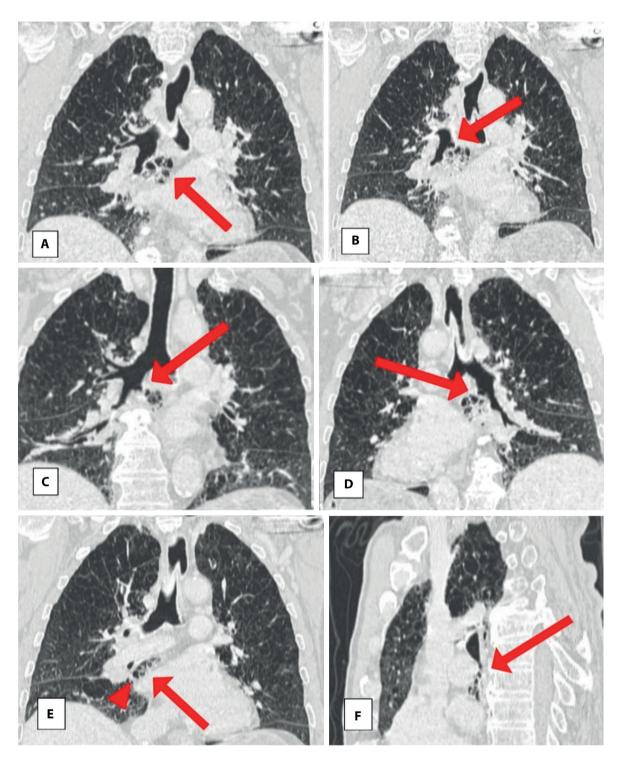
The reformatted chest CT scans. In the image a, a reformatted coronal chest CT scan shows an appearing cystic area in the right retrocardiac region (red arrow). Images b, c, and d show reformatted coronal chest CT scans with marked accessory cardiac bronchus (red arrow) arising from the medial wall of the intermediate bronchus with a correspondent lobule. In image e, the reformatted coronal chest CT scan shows an accessory cardiac lobe (red arrow) parallel with the intermediate bronchus and fissure of the lobule (red arrowhead). In image f, the sagittal reformatted chest CT scan demonstrates an accessory bronchus with corresponding pulmonary parenchyma in the retrocardiac region (red arrow).
